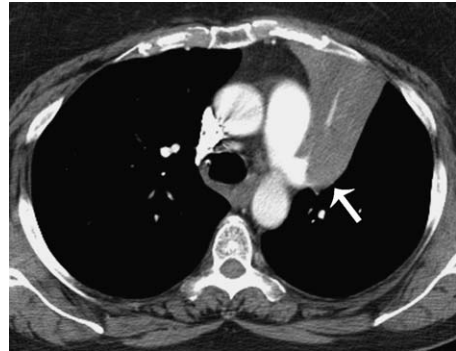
A 60-year-old man with T2 non-small cell lung cancer. Axial image from a contrast-enhanced CT scan shows that the primary tumor is located centrally (arrow), causing distal postobstructive atelectasis. Note the difficulty of differentiating tumor from collapsed lung parenchyma.
